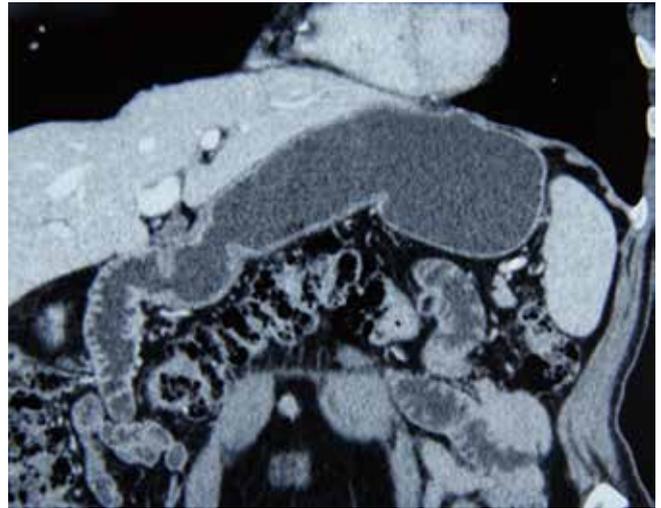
Three-dimensional reconstructive CT showed thickened wall in gastric antrum and visible enlarged lymph nodes along lesser curvature.
